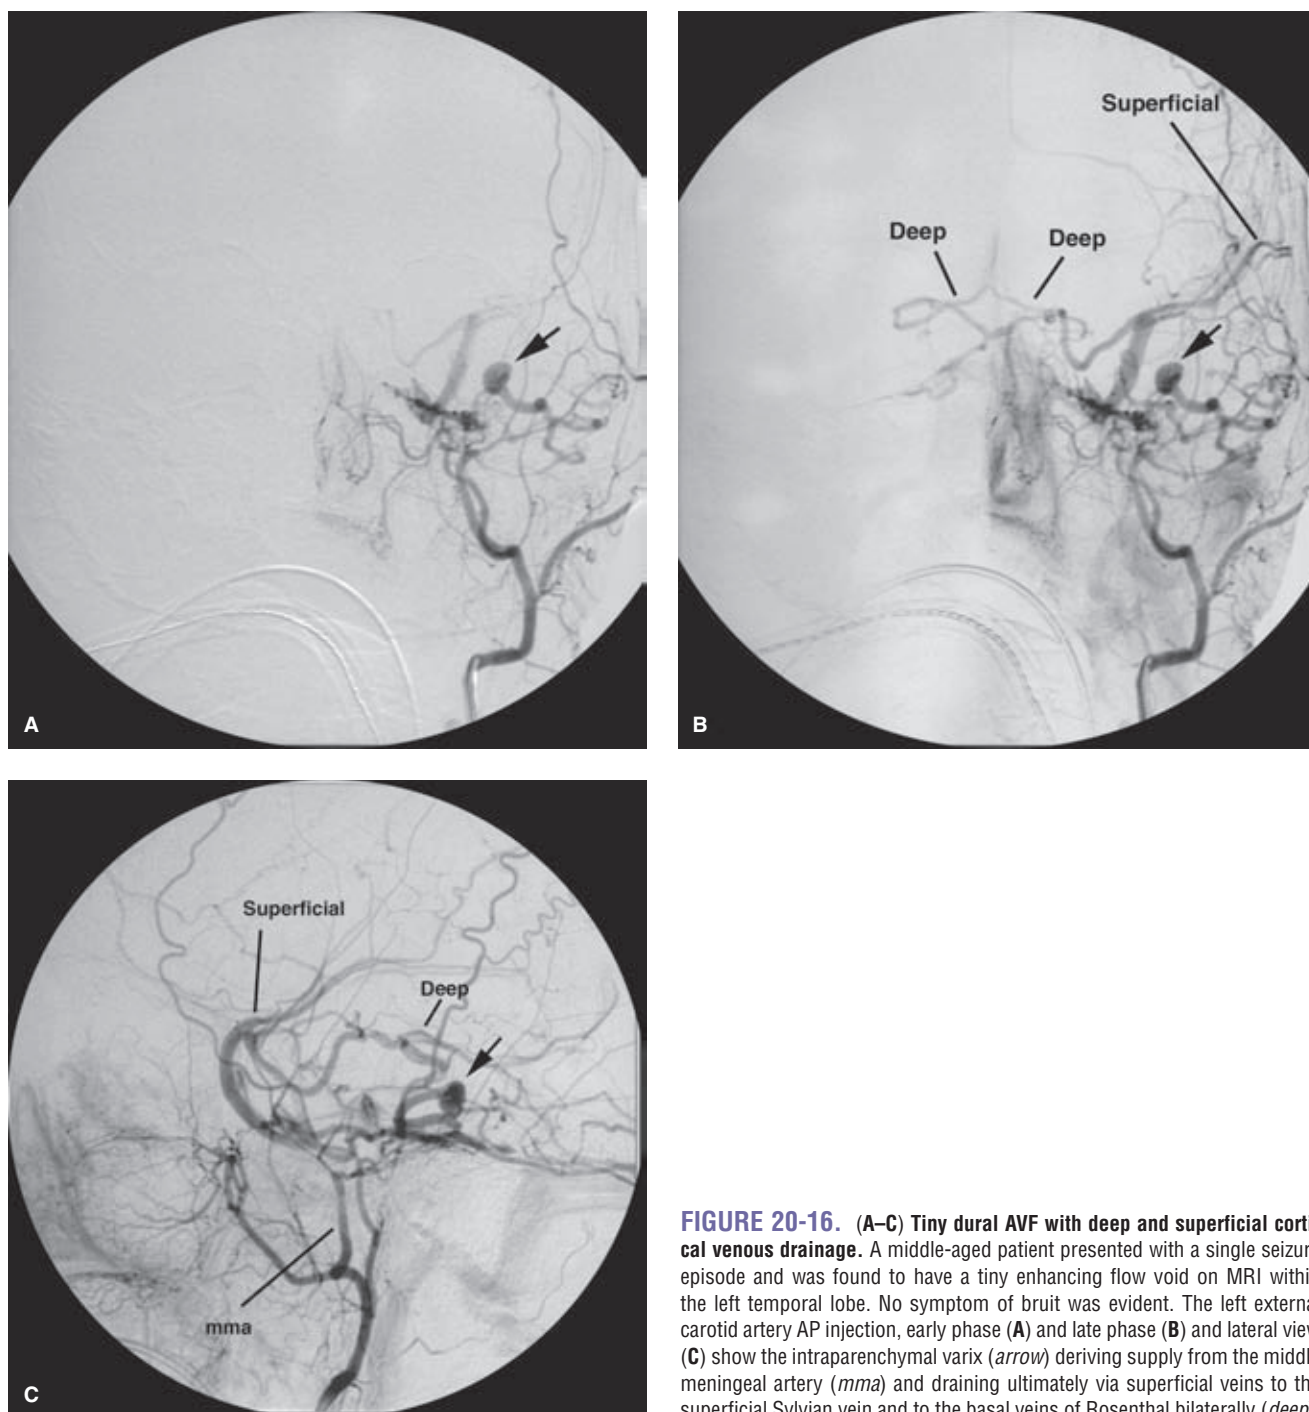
(A–C) Tiny dural AVF with deep and superficial cortical venous drainage. A middle-aged patient presented with a single seizure episode and was found to have a tiny enhancing flow void on MRI within the left temporal lobe. No symptom of bruit was evident. The left external carotid artery AP injection, early phase (A) and late phase (B) and lateral view (C) show the intraparenchymal varix (arrow) deriving supply from the middle meningeal artery (*mma*) and draining ultimately via superficial veins to the superficial Sylvian vein and to the basal veins of Rosenthal bilaterally (*deep*).
